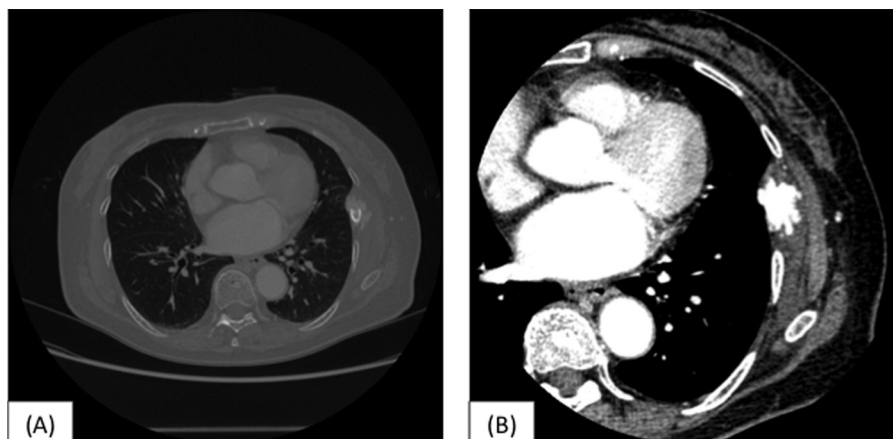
Chest CT examination revealed (A) an expanding osteolytic tumor and (B) enhancement by contrast medium.
